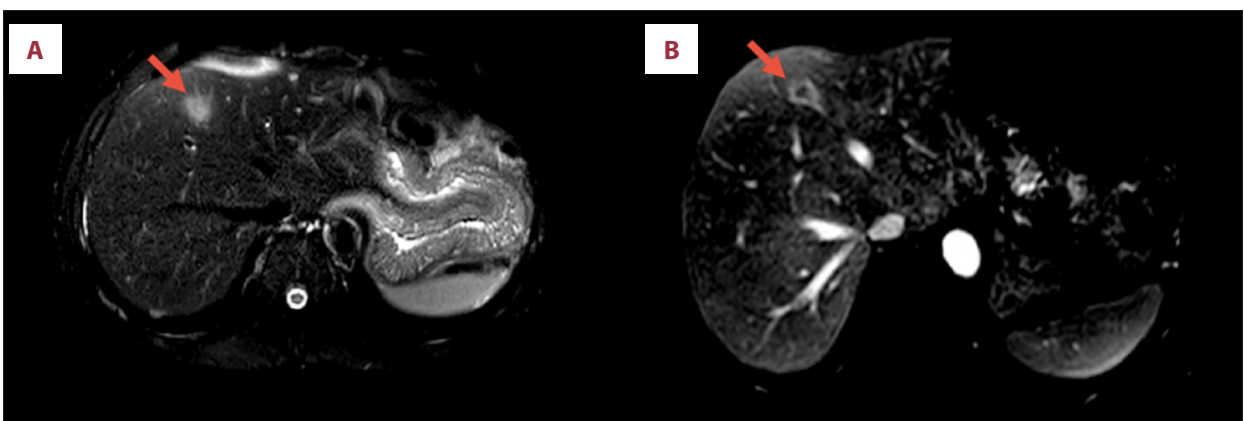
(A) Follow-up T2-weighted magnetic resonance image with fat saturation and (B) Post contrast T1-weighted image with fat saturation 1 month later demonstrate high T2 signal intensity and peripheral enhancement of the lesion, respectively, in keeping with metastasis from the colonic adenocarcinoma.
